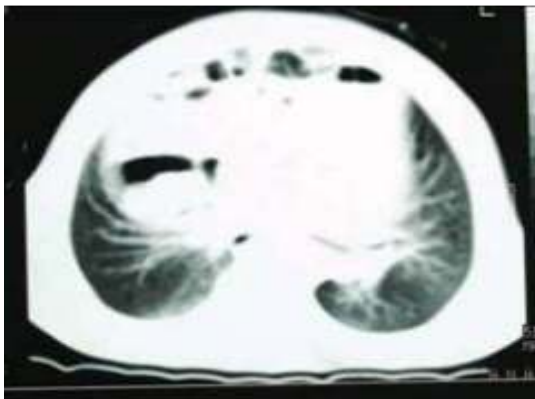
Computed tomography image showing multiple bowel loops within the right thoracic cavity (white arrow) consistent with a Morgagni hernia. The diaphragm can be identified below the hernia contents.
